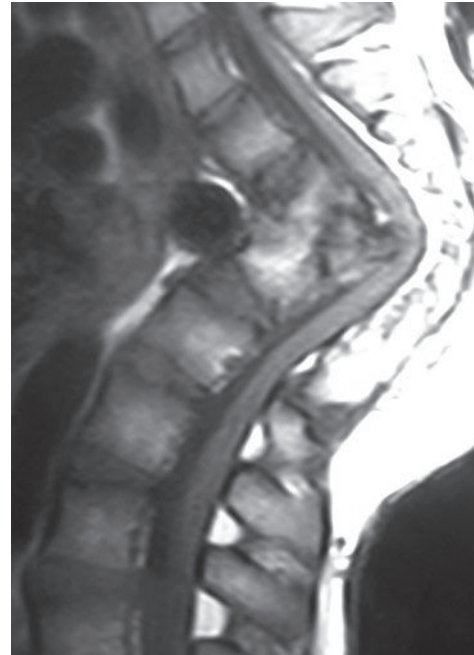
In this 16-year-old girl with a history of tuberculosis, a sagittal T1-weighted image shows destruction of three consecutive mid-thoracic vertebral bodies with associated kyphosis and gibbus deformity, compatible with tuberculous osteomyelitis.
